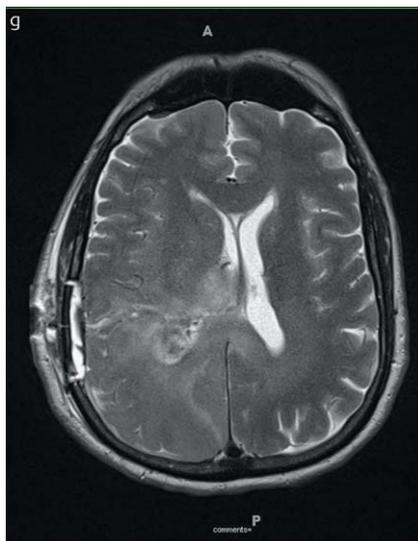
Post-operative T₂/FLAIR imaging demonstrating minimal signal change along surgical tract.
